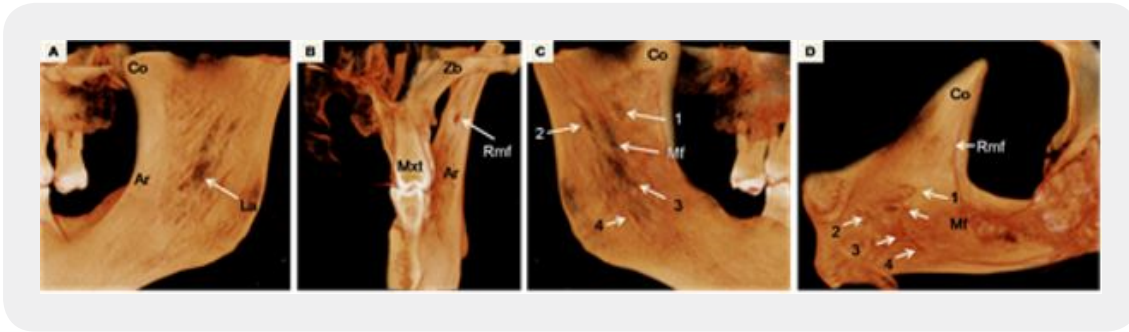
3D CBCT scan images left side of ramus of mandible A showing Co coronoid process; Ar ascending border of ramus; La Lateral accessory foramen on ramus along with bony irregularities aspect showing Mxt maxillary teeth; Zb zygomatic buttress; Ar ascending border of ramus; Rmf retromolar foramen C showing medial aspect of ramus Co coronoid process; Mf mandibular foramen; 1, 2, 3 & 4 multiple accessory foramina with bony strictions (possible canals) and irregularities on the lingual aspect D showing medial aspect from top Co coronoid process; Rmf retromolar foramen; Mf mandibular foramen; 1, 2, 3 & 4 accessory foramina
